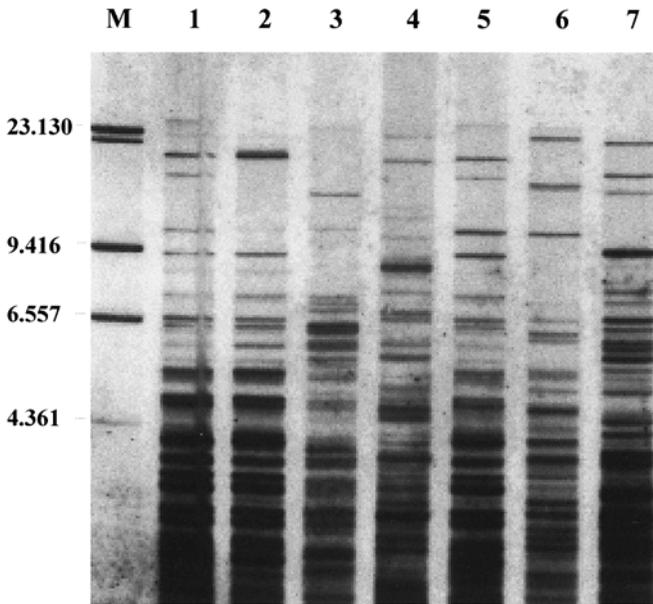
Multi-locus (GTG)₅ DNA profiles of human cell lines. The autoradiograph shows a multi-locus DNA fingerprint using (GTG)₅ oligomers as a probe. 10 µg of DNA of indicated cell lines were digested to completion, size-separated on a 0.7% agarose gel, and blotted onto a nylon membrane. After hybridization with (GTG)₅ and washing procedures, a chemiluminescent detection of the probe was carried out as described in Subheading 3.3. The blot was exposed for 30 min to an X-ray film. Lanes M and 1–7: BEWO, human choriocarcinoma; JAR, human choriocarcinoma (derivative of BEWO); JVM-2, human chronic B cell leukemia; NK-92, human natural killer lymphoma; MOLT-14, human T cell leukemia; 5637, human urinary bladder carcinoma; PEER, human T-cell leukemia.
